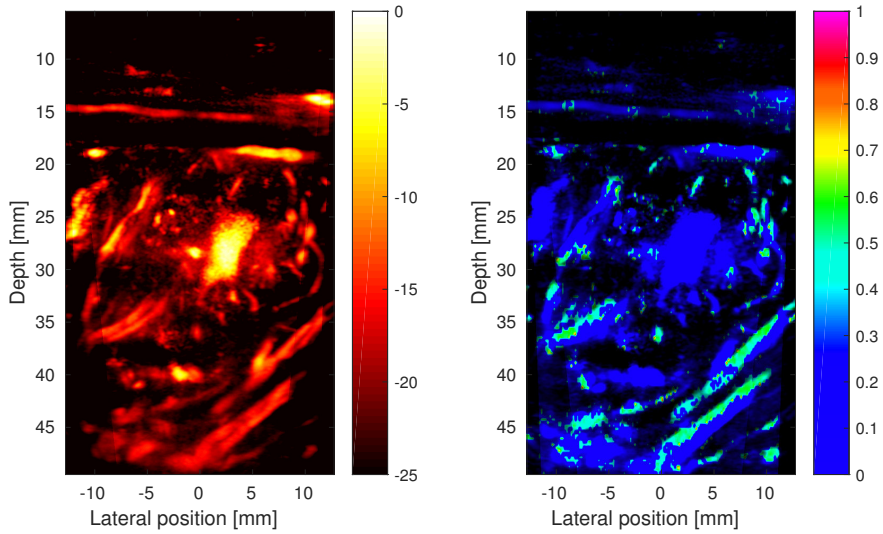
Power Doppler image (left) and the RI map of the fetal arteries after applying the discrimination algorithm (right) for volunteer I.
